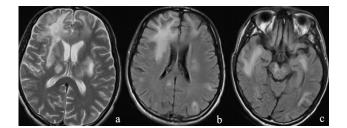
Progressive multifocal leukoencephalopathy; axial T2 weighted (a) FLAIR (b and c) bifrontal, left parietal and bitemporal white matter hyperintensities with involvement of the subcortical white matter/U-fibres.¹⁸
